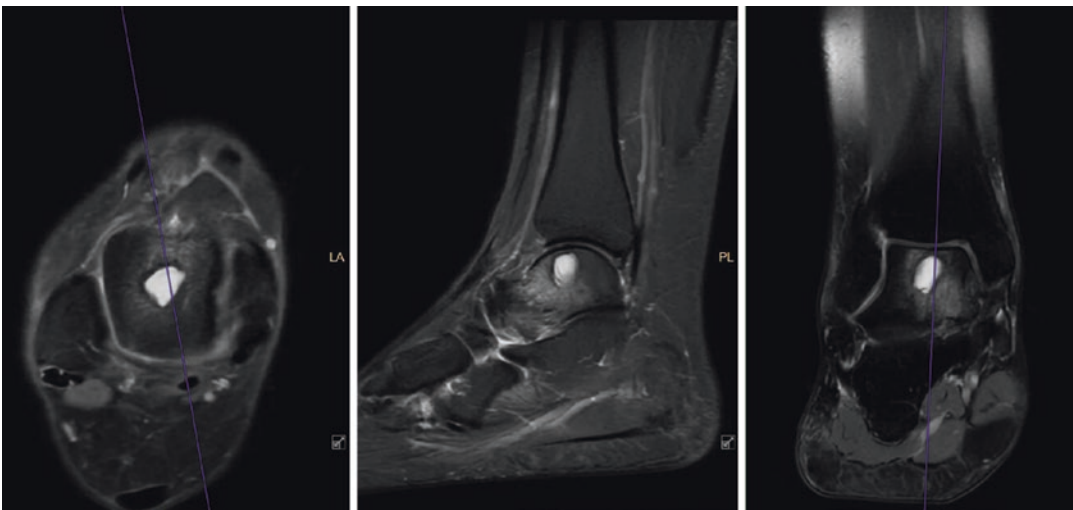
MRI demonstrates a large talar subchondral cyst. Defining the location and size of the cyst is important for surgical planning
